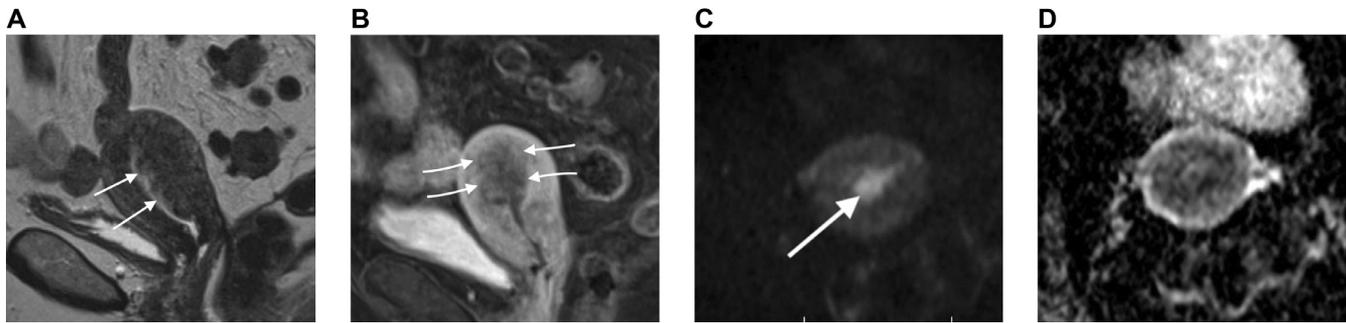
35-year-old woman. Hysterectomy showed Stage IA endometrioid cancer limited to the endometrium and adenomyosis. (A) Sagittal T2-weighted sequence shows irregular mixed signal thickening (arrows) of the dorsal endometrium in the body and lower uterine segment in a patient with history of trachelectomy. There is poor definition of the junctional zone with thick dorsal myometrium; (B) Sagittal T1-weighted + gadolinium sequence shows poor definition of the endometrium in the upper body of the uterus (arrows) in a patient with history of trachelectomy; (C) Axial DWI sequence (B value 1000) shows focal high signal thickening (arrow) of the endometrium; (D) Axial ADC map shows no diffusion restriction corresponding to the high signal area on DWI sequence due to the low grade of the cancer.
